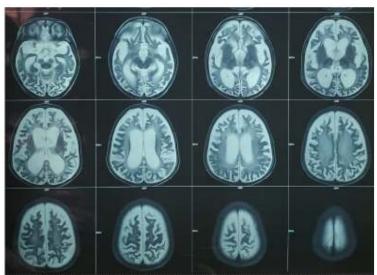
Magnetic resonance imaging of the brain showing ventriculomegaly, cerebral atrophy and hyper-intensity in bilateral periventricular, deep and subcortical white matter.
